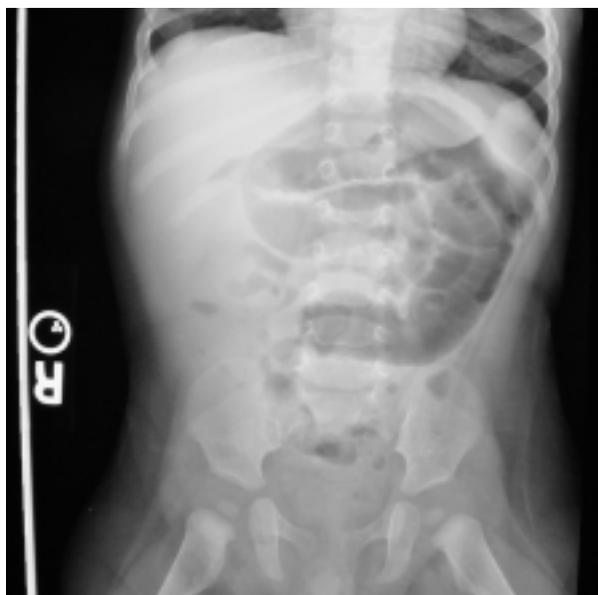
Abdominal radiograph of the case patient, revealing dilated loops of small bowel, obstruction of the liver edge, and a paucity of rectosigmoid gas. There is no evidence of perforation.
